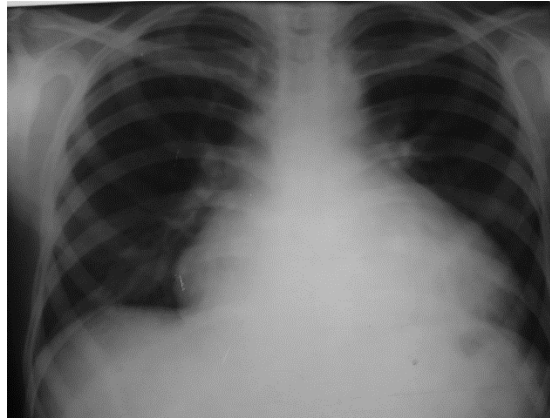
Chest X-ray demonstrating dilation of the heart in patient with traumatic heart defect
